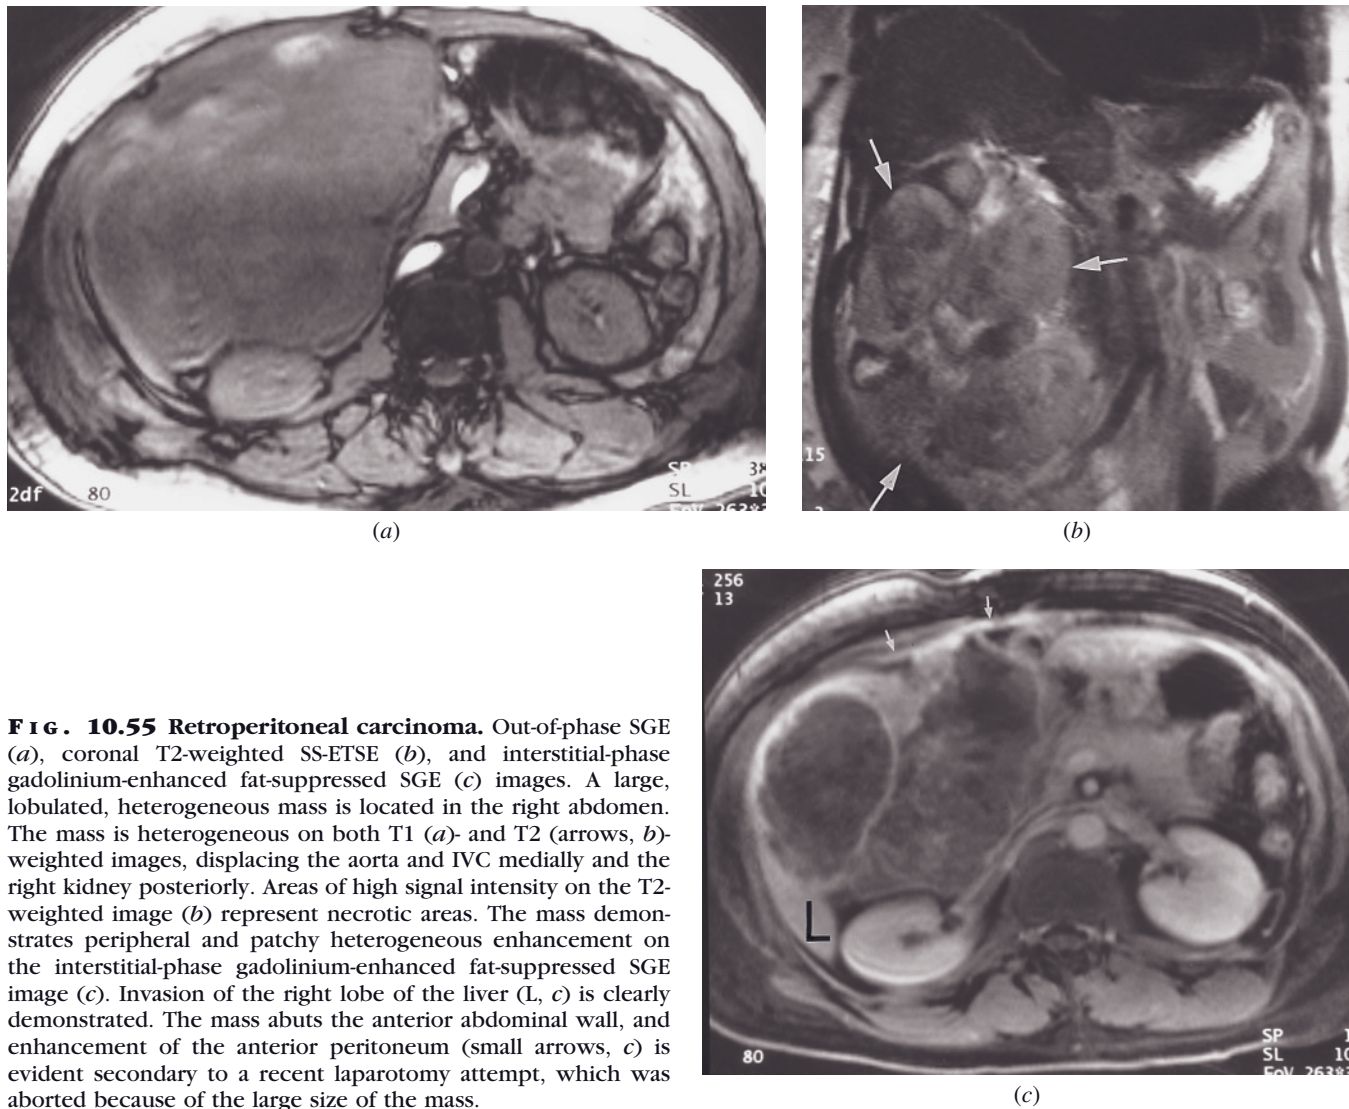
Retroperitoneal carcinoma. Out-of-phase SGE (a), coronal T2-weighted SS-ETSE (b), and interstitial-phase gadolinium-enhanced fat-suppressed SGE (c) images. A large, lobulated, heterogeneous mass is located in the right abdomen. The mass is heterogeneous on both T1 (a)- and T2 (arrows, b)-weighted images, displacing the aorta and IVC medially and the right kidney posteriorly. Areas of high signal intensity on the T2-weighted image (b) represent necrotic areas. The mass demonstrates peripheral and patchy heterogeneous enhancement on the interstitial-phase gadolinium-enhanced fat-suppressed SGE image (c). Invasion of the right lobe of the liver (L, c) is clearly demonstrated. The mass abuts the anterior abdominal wall, and enhancement of the anterior peritoneum (small arrows, c) is evident secondary to a recent laparotomy attempt, which was aborted because of the large size of the mass.
